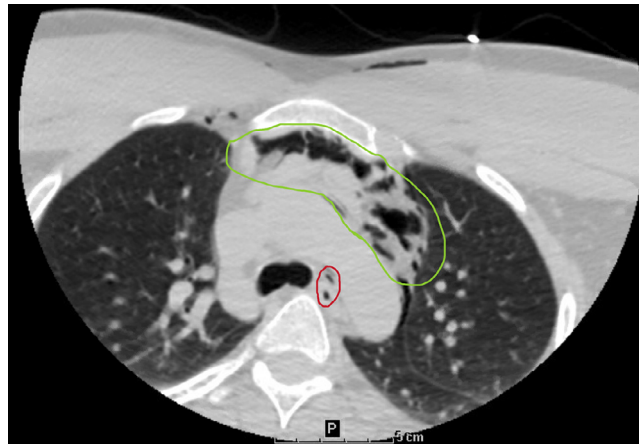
Axial view of a computed tomography (CT) neck scan without contrast at the level of the fifth thoracic vertebrae. There is air in the anterior (green) and posterior (red) mediastinum.
